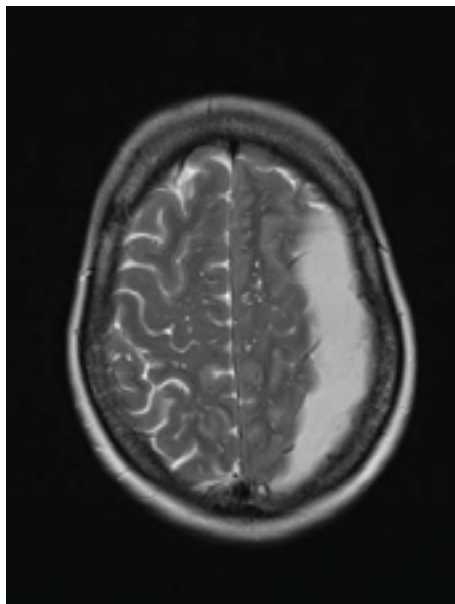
The same patient underwent an MRI scan which as shown on the T2 weighted sequence confirms a left sided chronic subdural haematoma.
